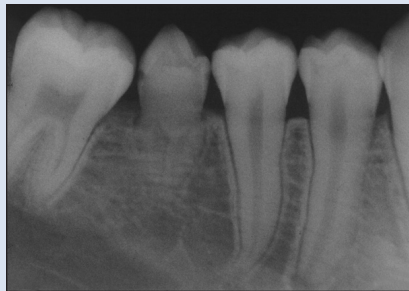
Periapical radiograph of the supplemental premolar taken 40 months after autotransplantation shows completed root growth with partial pulp obliteration.
